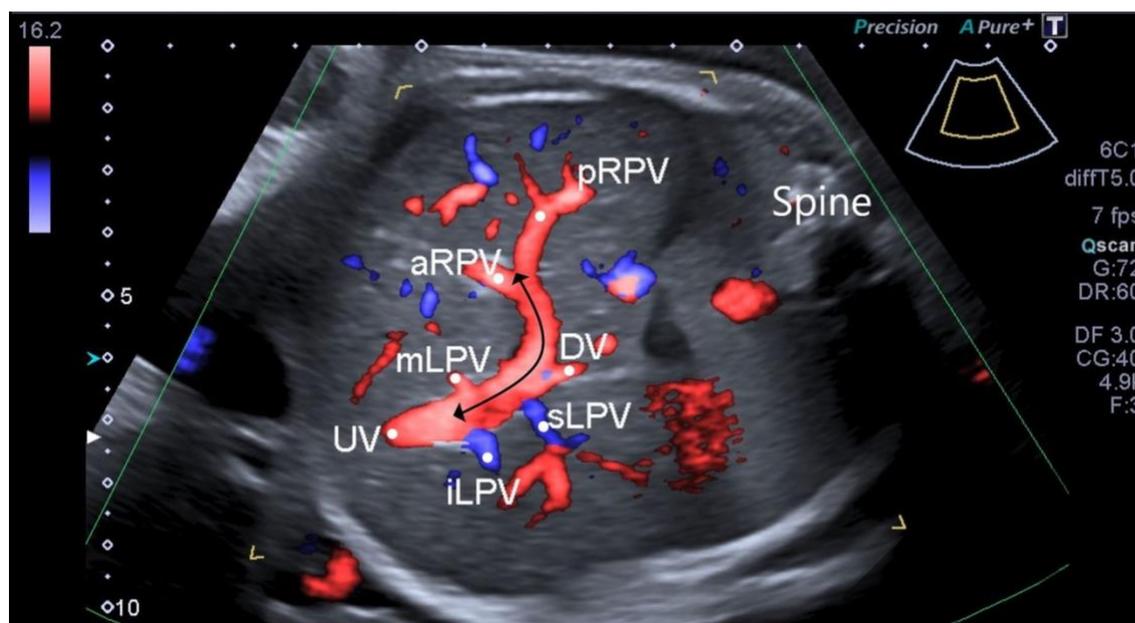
Afferent precordial venous system in an oblique axial color Doppler image. UV=Umbilical Vein, iLPV=Inferior branch of the left portal vein, sLPV=superior branch of the Left Portal Vein, DV=Ductus Venosus, Curved black line =Portal Sinus, mLPV= Medial branch of Left Portal Vein, aRPV=Anterior branch of the Right Portal Vein, pRPV=Posterior branch of the Right Portal Vein
